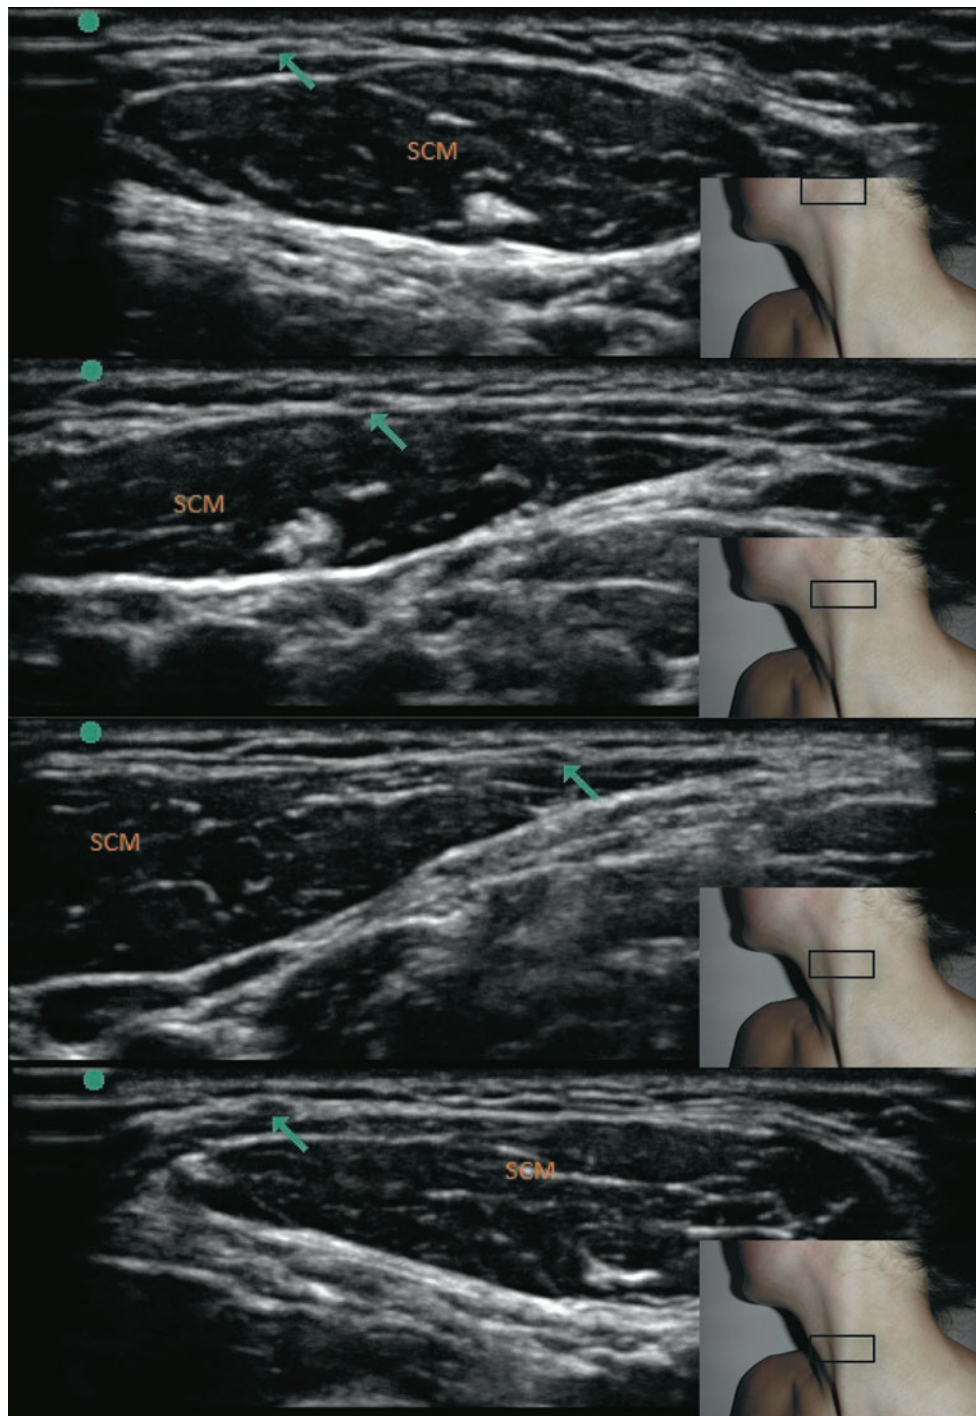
Ultrasound examination of the posterior auricular/great auricular nerve. *SCM* sternocleidomastoid muscle. *Green arrow* = great auricular nerve (Images courtesy of Agnes Stogicza, MD)
